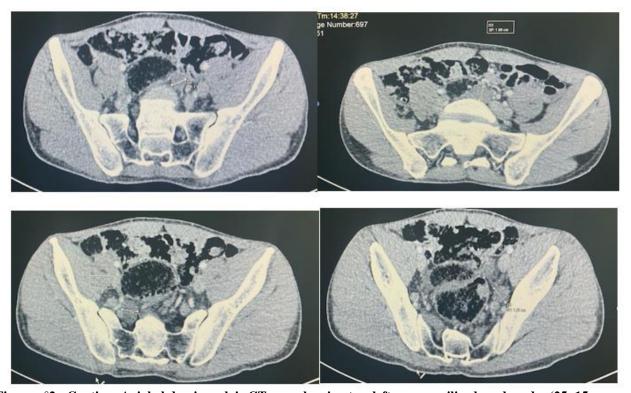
Caption: Axial abdominopelvic CT scan showing two left common iliac lymph nodes (25×15 mm and 14×15 mm), and two internal iliac lymph nodes on the right and left (24×19 mm and 16×22 mm, respectively)
